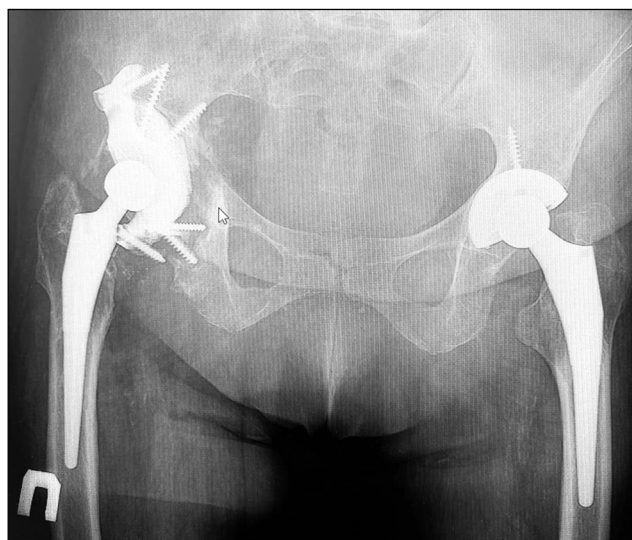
Postoperative control X-ray 4 years after the operation.
